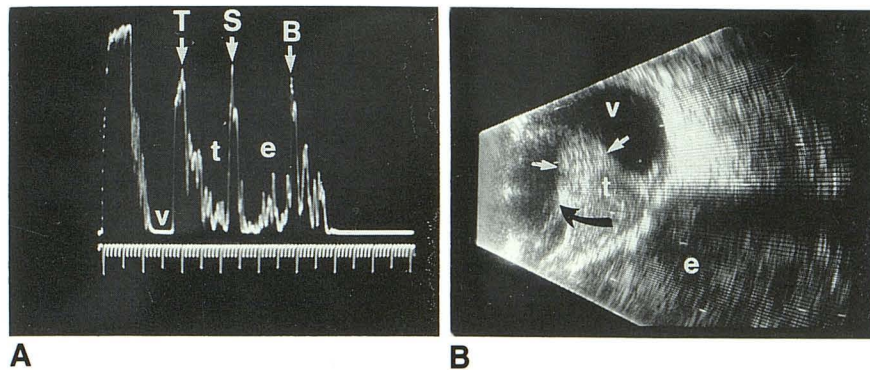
A, A-mode ultrasound shows a steep spike of tumor surface with subsequent decreasing echoes anterior to the scleral spike. Posteriorly, low reflective echoes indicate extraocular tumor. *v* indicates vitreous body; *T*, tumor surface; *t*, tumor; *S*, sclera; *e*, extraocular tumor; and *B*, bone.
